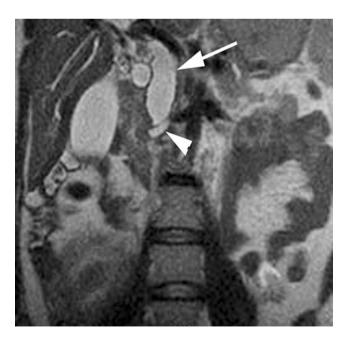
Coronal section from T2 weighted magnetic resonance image depicts marked dilatation of the common bile duct (*arrow*) and pancreatic duct (*arrowhead*).
